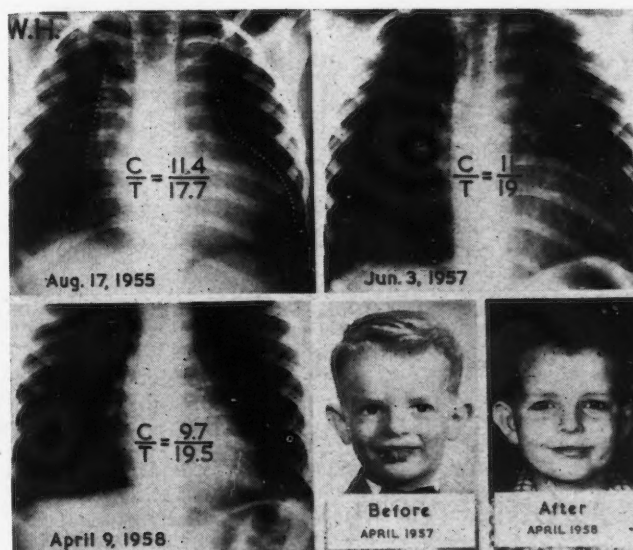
The hypotensive effect of bilateral adrenalectomy in Case 7 is revealed by the marked decrease in cardiac size: adrenalectomy was completed immediately after the radiograph of June 3, 1957. The alteration in facies of the boy is factual, though apparent change in the hair colour is a photographic artefact.
